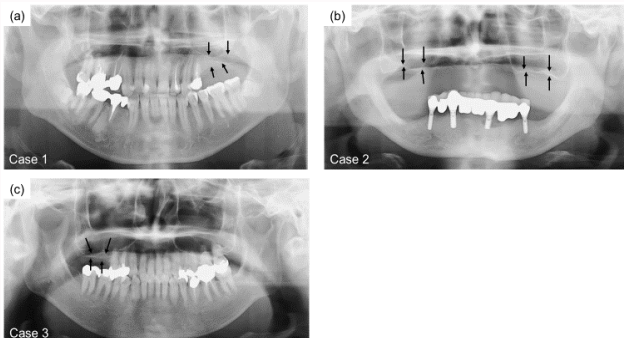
X-ray images of maxillary atrophic patients. (a) Case 1, the right maxilla. (b) Case 2, bilateral maxilla. (c) Case 3, the left maxilla. Arrows show the height of the alveolar crest relative to the sinus floor. The thickness of bone from the alveolar crest to the sinus floor in each case was 1 mm to 5 mm. Bone augmentation was necessary for dental implant treatment.
